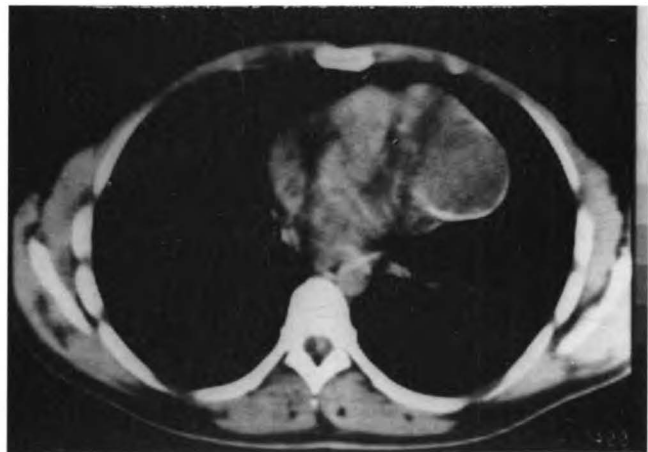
CT scan of thymic lymphoma with a large thymic cyst. Note the peripheral rimming by calcification. (Bar - 10 cm).
